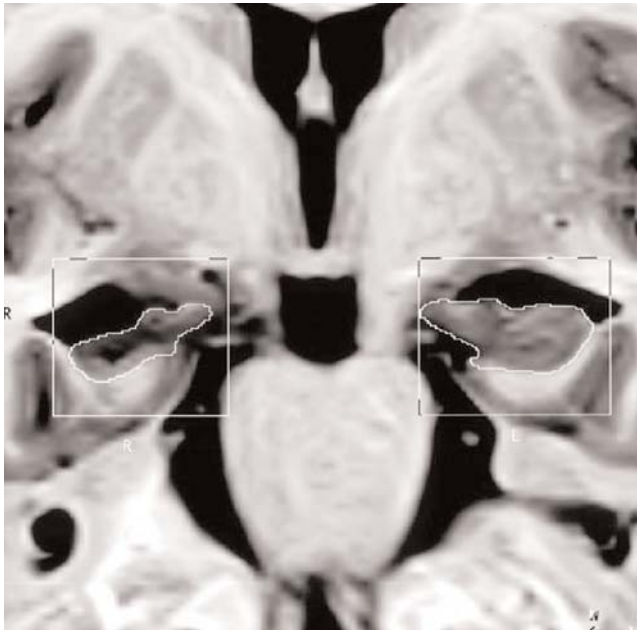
Hippocampal area measurement. From "Morphometry of some elements of limbic system in normal population: a quantitative MRI study" by Yücel K, Hakyemez B, Parlak M, Oygucu IH. Neuroanatomy 2002;1:15–21.^[33] © neuroanatomy.org. Reprinted with permission.
